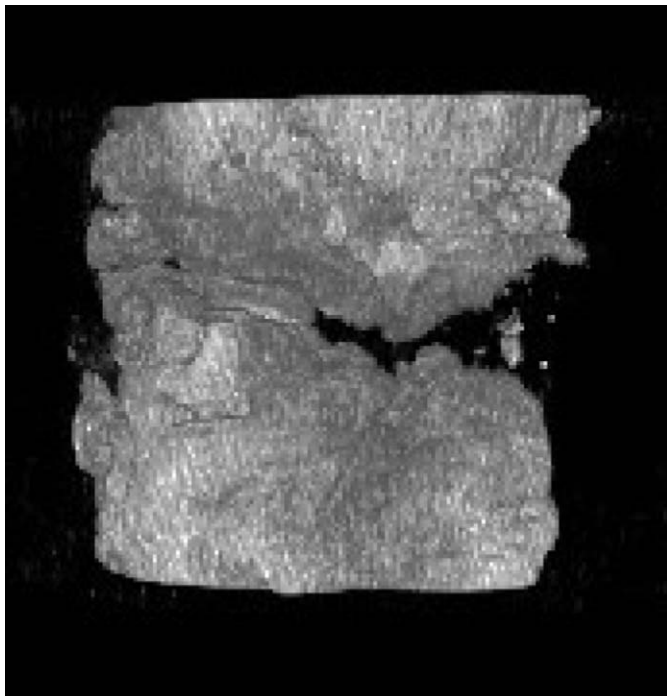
Three-dimensional image of mineralized bone in a PRP-treated defect performed by the  $\mu$ -CT scanner at 100  $\mu$ m spatial resolution. The edges of the defect at the top and bottom of the image show intense new bone formation, however, there is no complete bridging of the defect.
